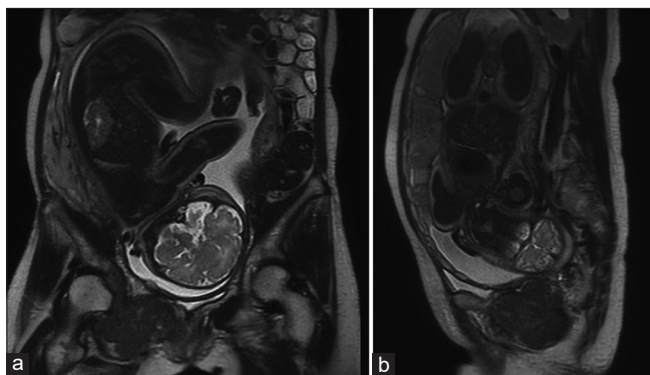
MRI. (a) Coronal view. (b) Axial view. Ischium metastasis invasive to soft tissue is observed. No neonatal metastasis is observed
